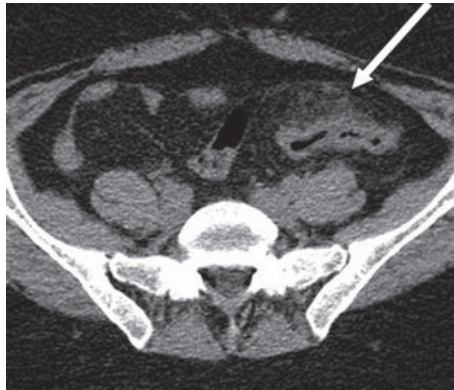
Unenhanced axial abdominopelvic CT image of a 39-year-old woman with abscess formation. The arrow shows the thickening of the sigmoid colon, with surrounding inflammatory changes (9)
